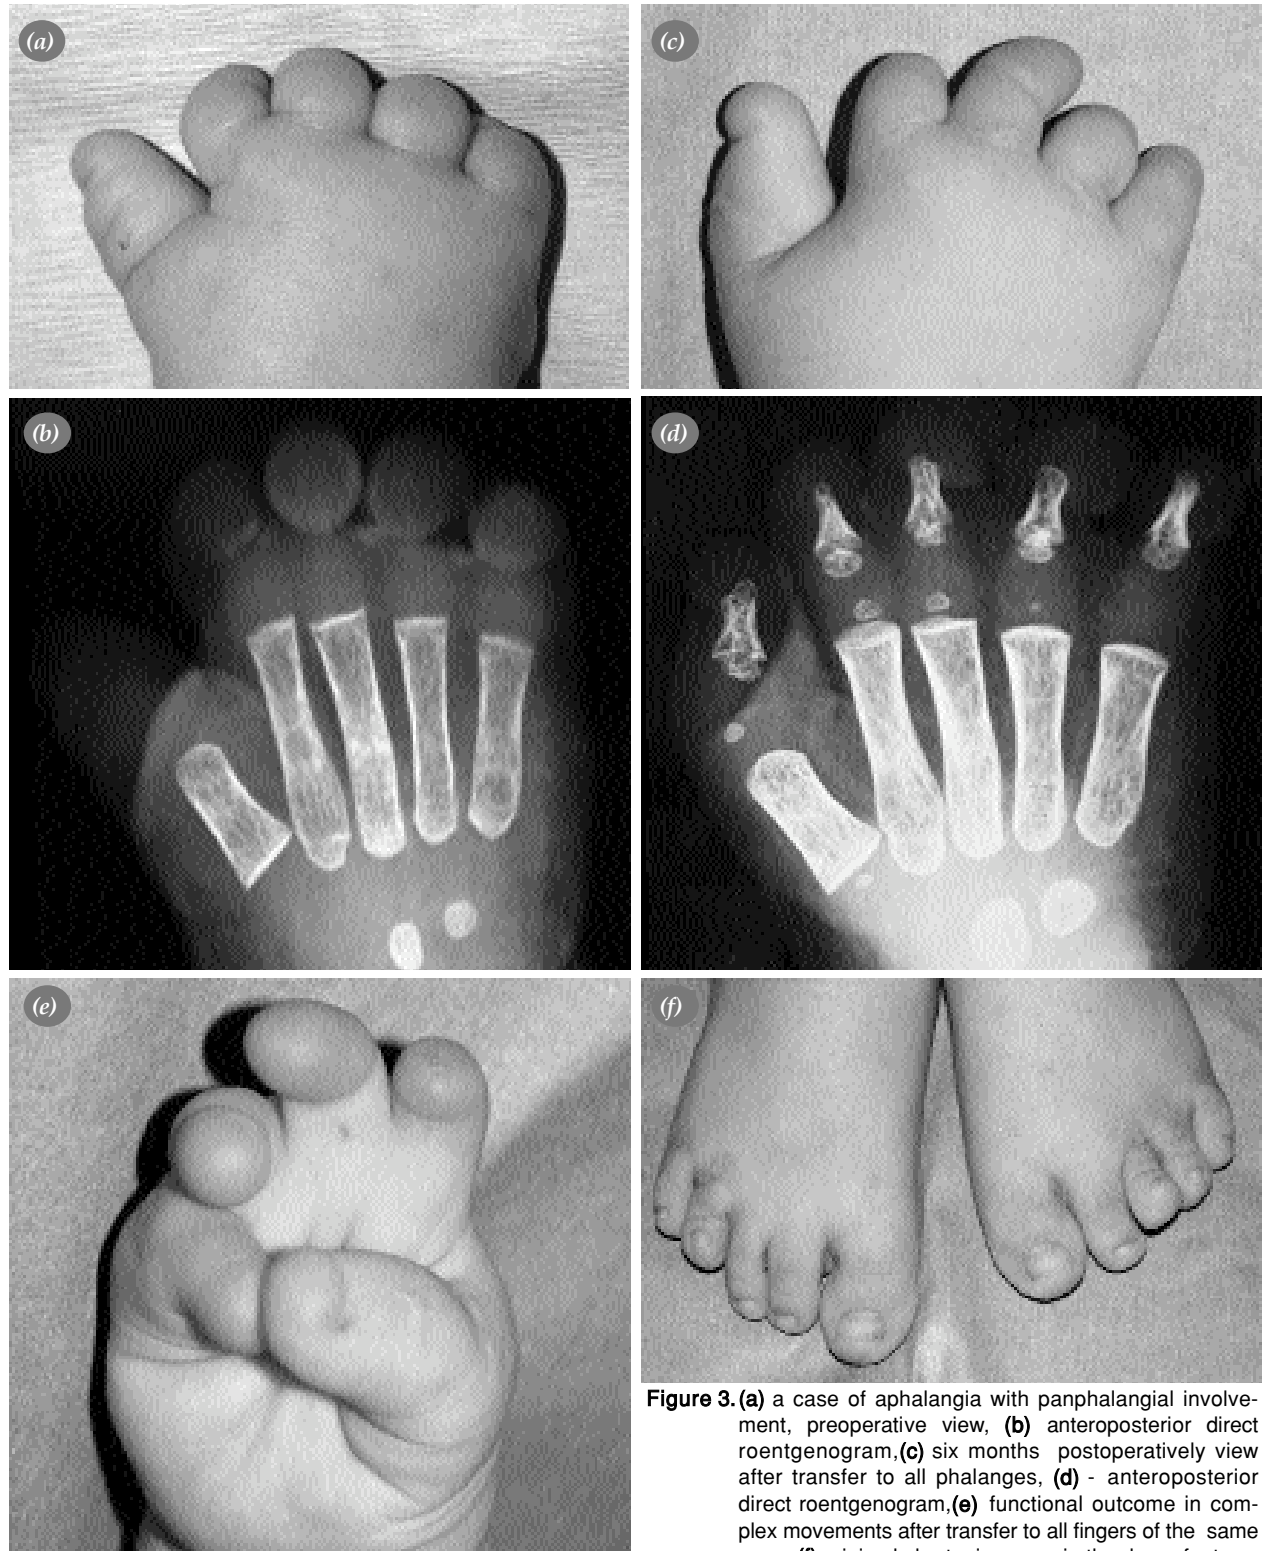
(a) a case of aphyalangia with panphalangeal involvement, preoperative view, (b) anteroposterior direct roentgenogram, (c) six months postoperatively view after transfer to all phalanges, (d) - anteroposterior direct roentgenogram, (e) functional outcome in complex movements after transfer to all fingers of the same case, (f) minimal shortening seen in the donor foot.
